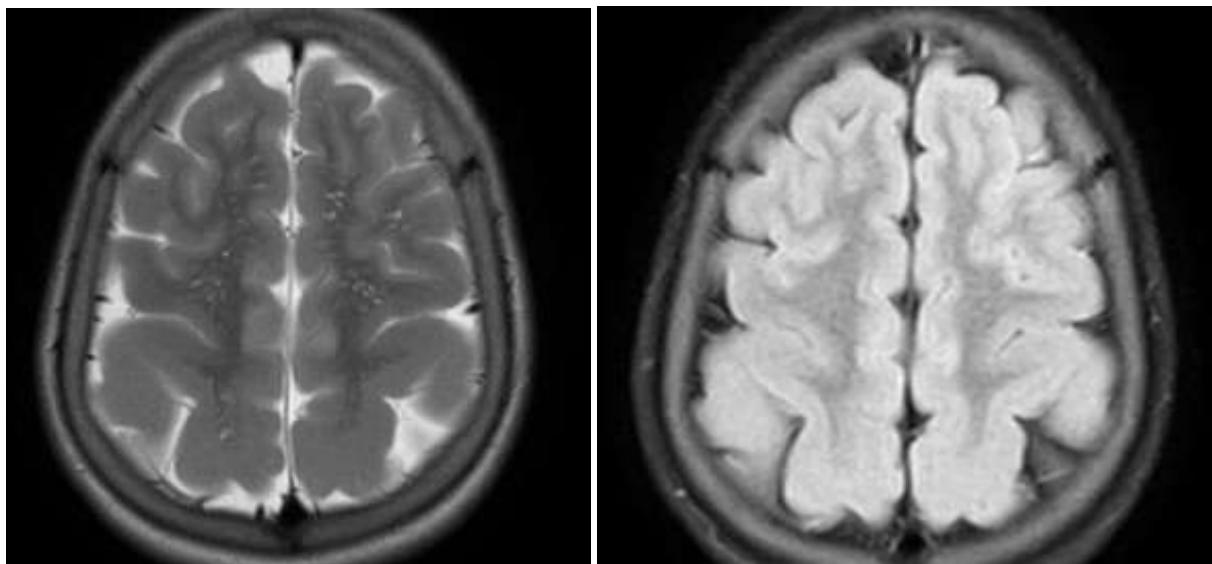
Axial T2W and FLAIR images multiple radiating subcortical hyperintensities (white arrows) suppressed on corresponding FLAIR image representing perivascular spaces
